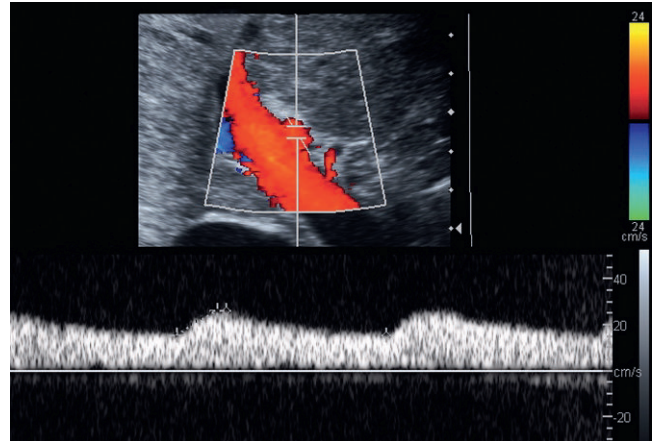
The color Doppler image of the porta shows an arterial waveform obtained from a right hepatic artery branch with tardus parvus changes. The right hepatic artery is being supplied by collaterals that developed in the setting of hepatic artery stent thrombosis.
